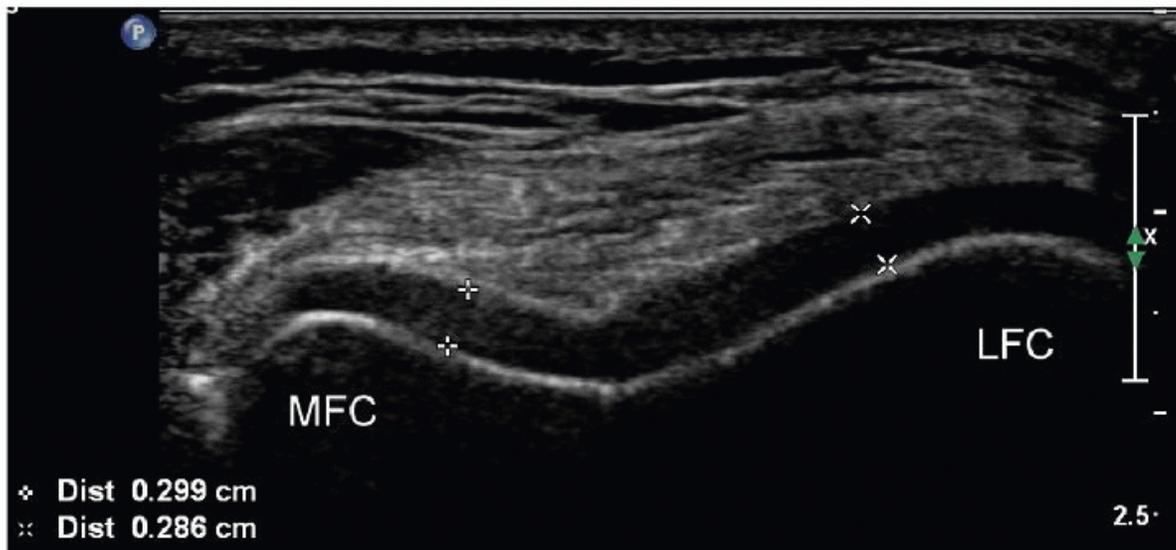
Transverse ultrasound image of the distal femur demonstrating the anechoic articular cartilage of the distal femur with measurements (calipers). MFC, medial femoral condyle; LFC, lateral femoral condyle.
